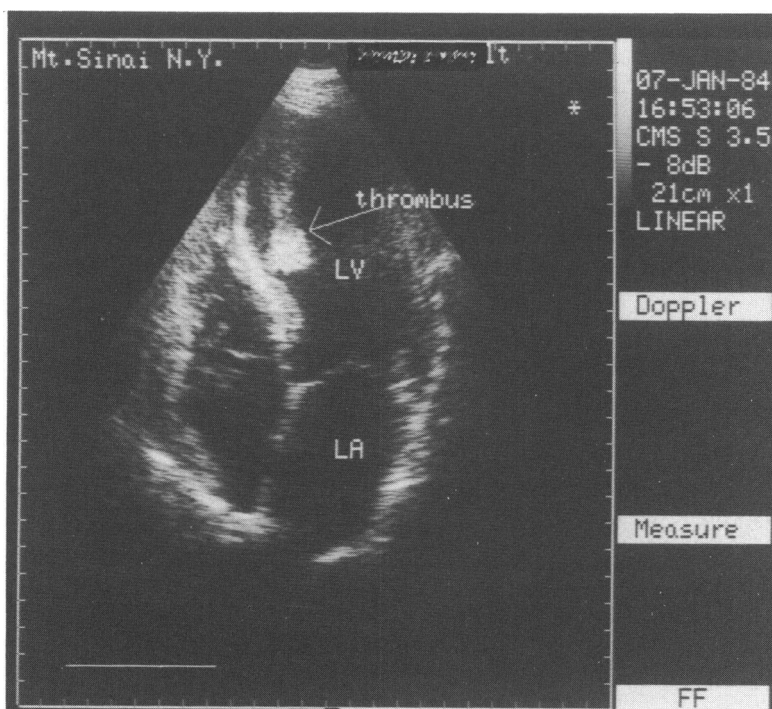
Left ventricular thrombus. In this apical four-chamber view, a large left ventricular thrombus is seen along an infarcted interventricular septum (arrow). LA=left, atrium, LV=left ventricle).
